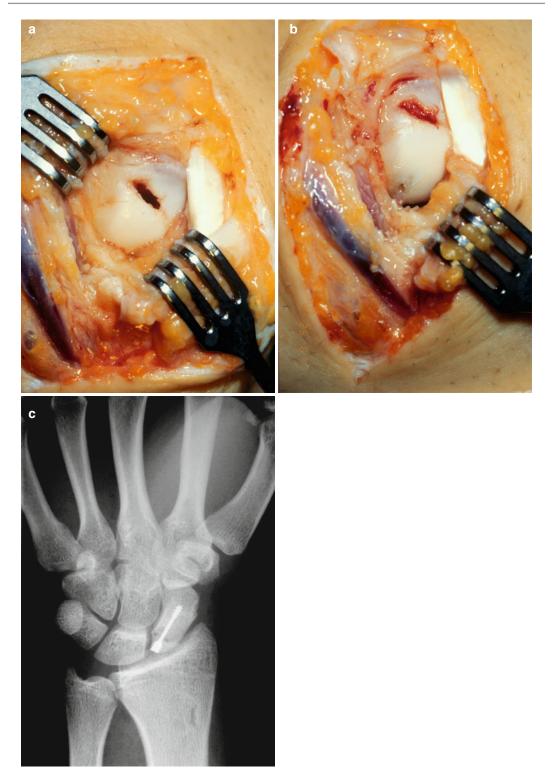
(a) Proximal pole non-union D1 (b) Local bone graft from radius preserving the shape of the scaphoid and fixation by Mini Herbert screw (c) Postoperative radiograph
